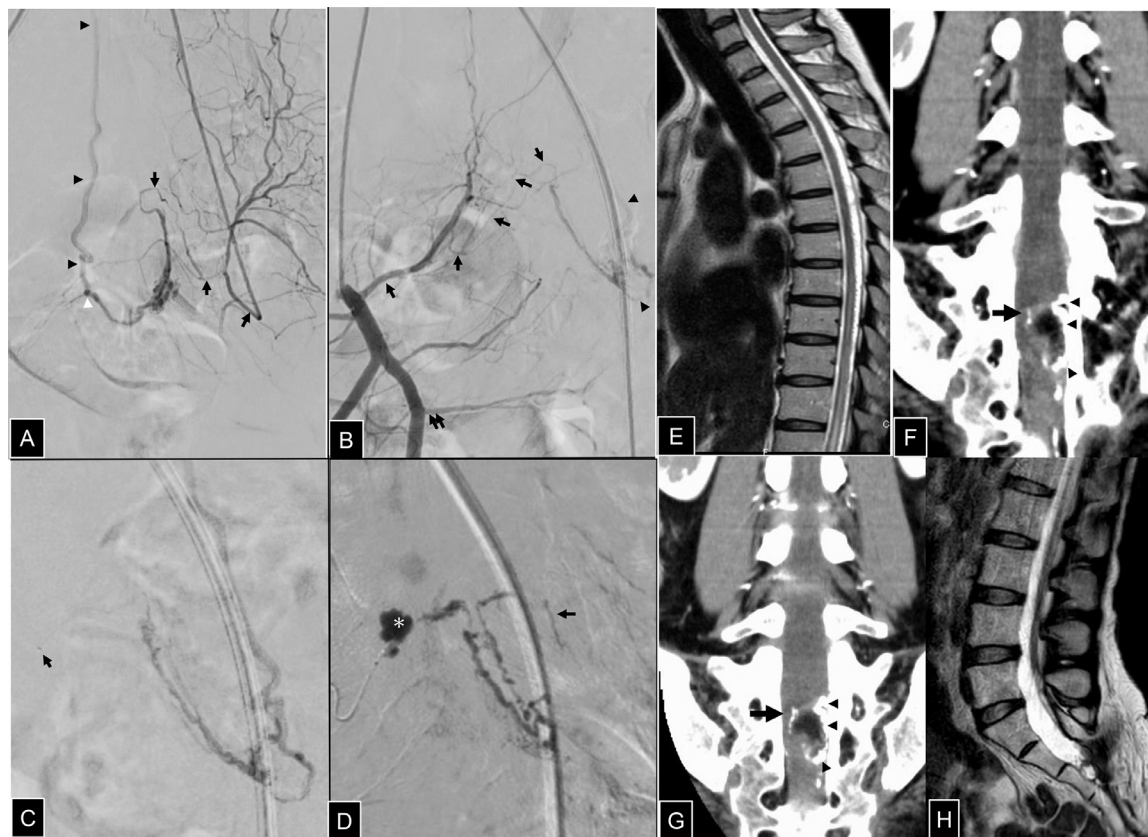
(A) Anterior-posterior view of angiography from left lateral sacral artery shows newly developed arteriovenous fistula arising from the left sacral artery (arrows). Draining vein is shown as black arrowheads. The white arrowhead indicates the site of the probable shunt point. (B) Lateral view of angiography from left lateral sacral artery. The arrows indicate the first sacral artery and draining vein is shown as black arrowhead. The white arrowhead indicates the site of the probable shunt point. The double arrows represent the third sacral artery which was embolized in the initial treatment. (C) Lateral view of angiography from the microcatheter prior to the embolization procedure. The arrow indicates the tip of the microcatheter, where embolization was initiated. (D) Embolization was performed with 0.13 ml of 16.7% N-butyl cyanoacrylate (NBCA) and it was injected into the fistulous tract, but extravasation occurred near the first sacral foramen at the end of the procedure (*). Black arrow indicates the NBCA casts have partially reached the draining vein. (E) Sagittal T2WI of MR imaging 11 days postoperatively (2 days after the second treatment). (F, G) Contrast-enhanced coronal CT image 17 days postoperatively (7 days after the second treatment). Black arrow indicates the NBCA casts have partially reached the draining vein. Black arrowheads show the vessels where the feeding artery was embolized with NBCA. (H) Sagittal T2WI of spinal MR imaging 3 months postoperatively.
